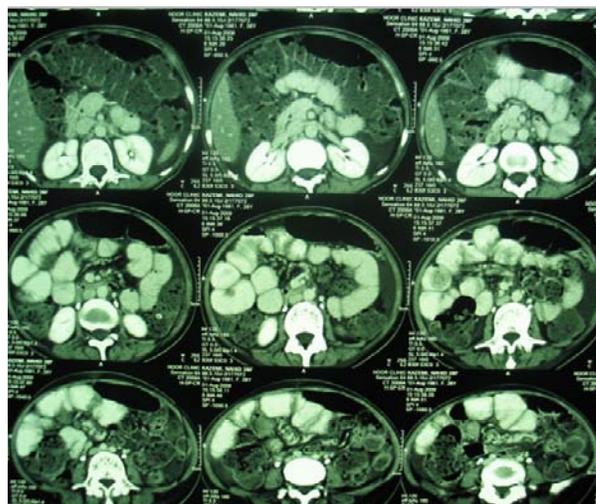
Abdominal computed tomography scan. A marked ascites, minimal left side pleural effusion and distention of small bowel loop dominantly jejunaileal (40mm) with normal wall thickness and normal wall thickness of colon with out demonstrating retroperitoneal and pelvic lymphopathy.
